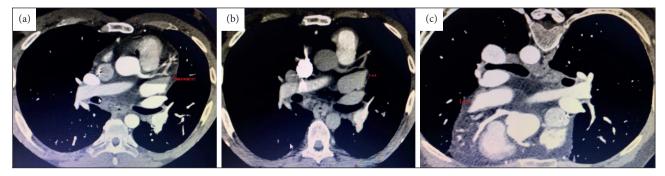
Computed tomography (CT): (a) first sequence with a filling defect in the LAA, (b) second delayed sequence showing complete filling of the LAA, (c) third sequence in prone position, showing complete filling of the LAA.
